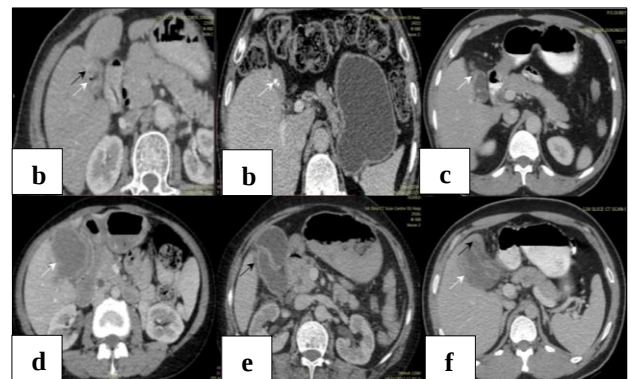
Contrast enhanced CT scan showing type I enhancement pattern in a thickened gall bladder wall, with various accompanying pathologies (a) homogeneously enhancing one layered wall or indistinguishable layer (white arrow) with associated focal mass lesion (black arrow), (b) with calculi inside the lumen (white arrow), (c) a homogenous wall enhancement and thickening (white arrow), (d) an inhomogeneous lesion in wall (white arrow), (e) presence of pericholecystic fluid (black arrow,) and (f) presence of pericholecystic fluid (black arrow) and non- visualised pericholecystic fascia (white arrow).
